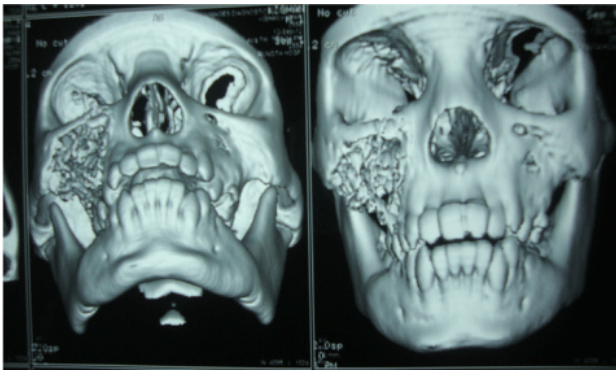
CT Scan: Sagittal view
